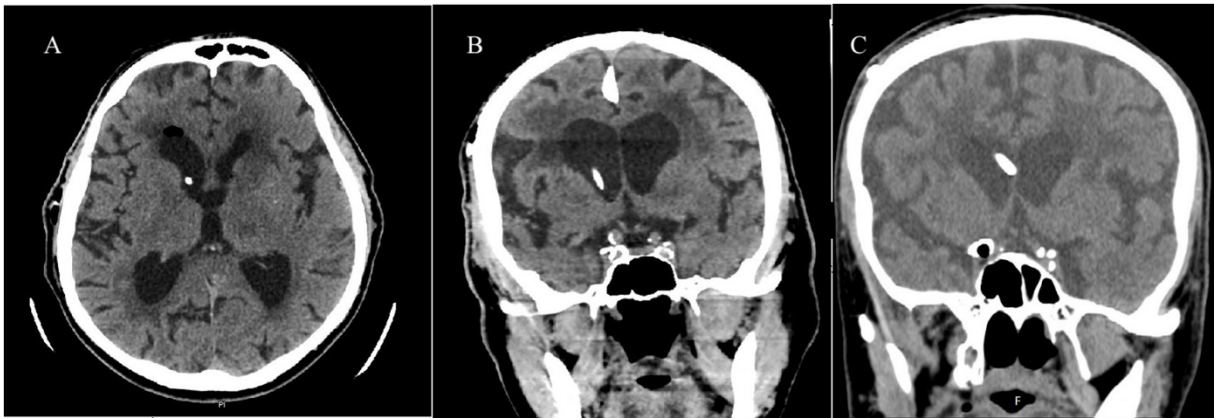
A: Grade I axial view non-contrast CT according to Hayhurst radiological grading, B: Grade I coronal CT scan without contrast, C: Grade II coronal CT scan without contrast
